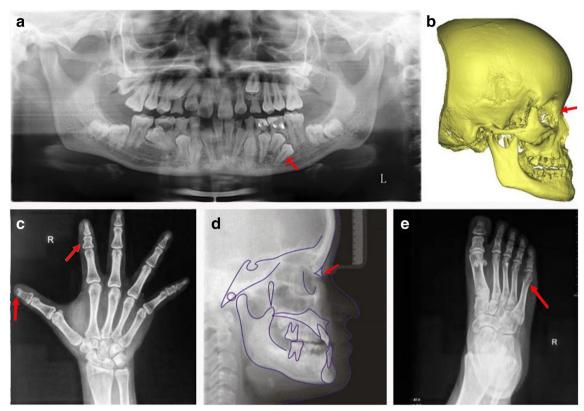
Radiological findings in the proband. a Panoramic radiograph showing many retained deciduous teeth and unerupted permanent teeth and one supernumerary tooth between the left second premolar and first molar in the mandible (indicated by red arrow). b 3D reconstruction of skull showing prominent forehead and no nasal bone (indicated by red
